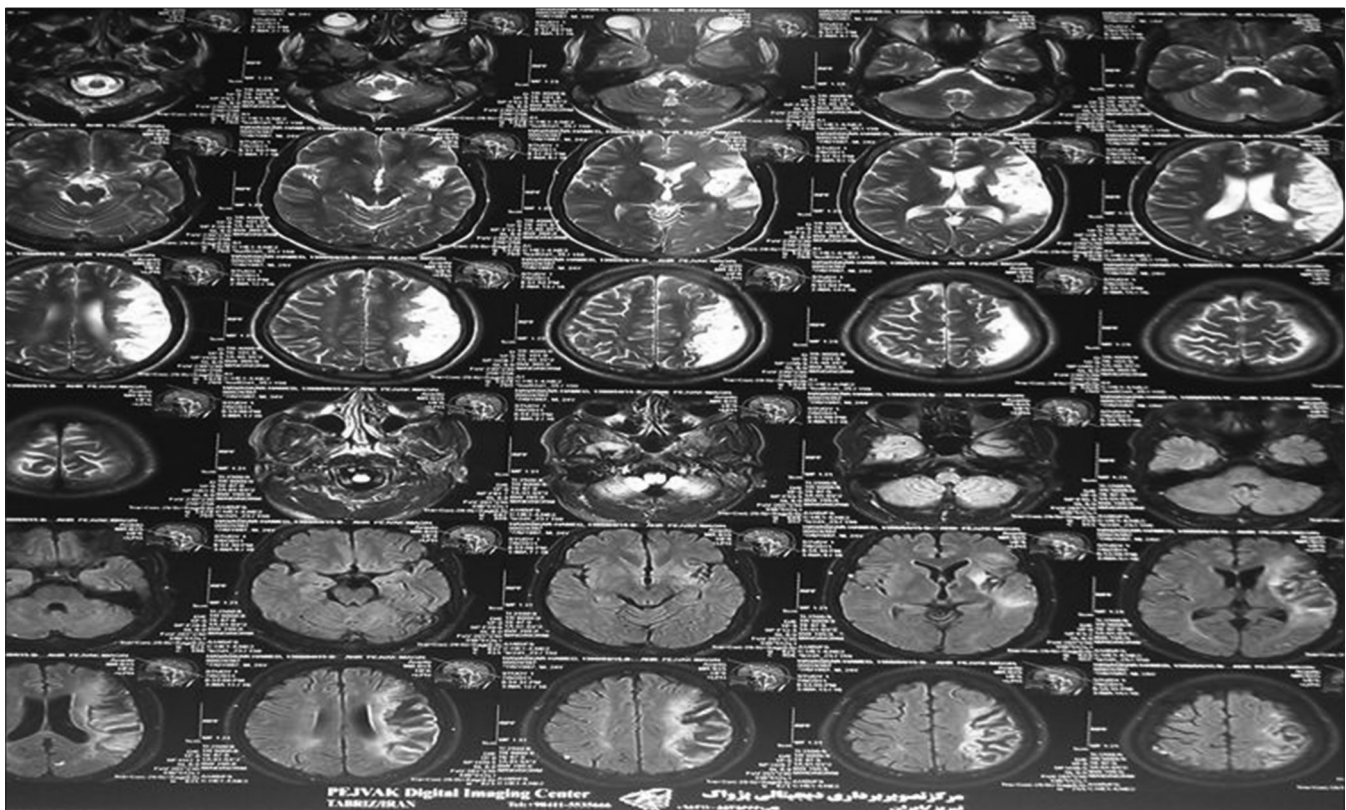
Patient's magnetic resonance imaging 12 months after admission
